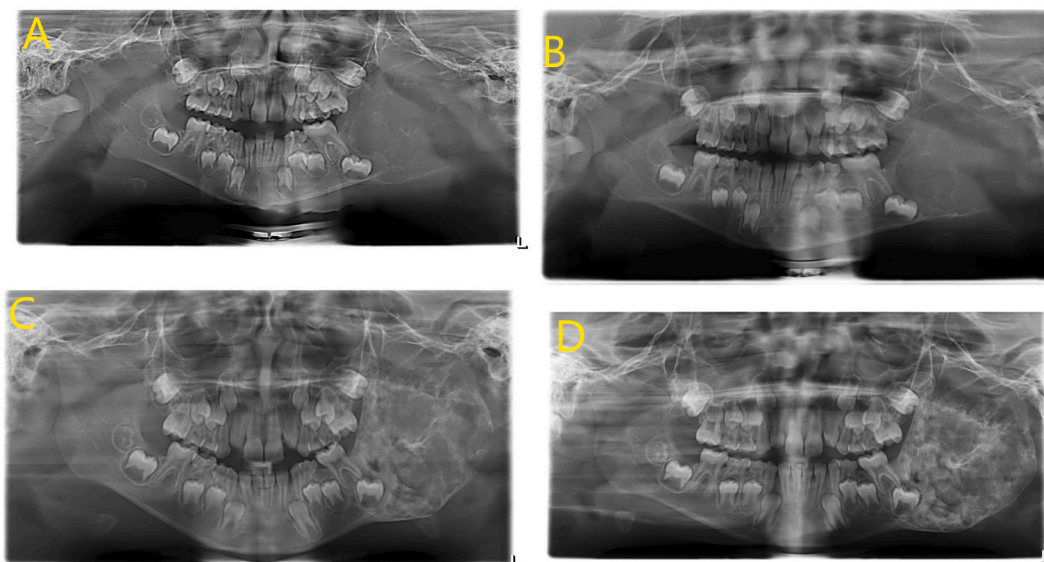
Panelipse radiographs depicting gradual calcifications: A- Initial, B- 3 months, C- 6 months, D- 9 months.
